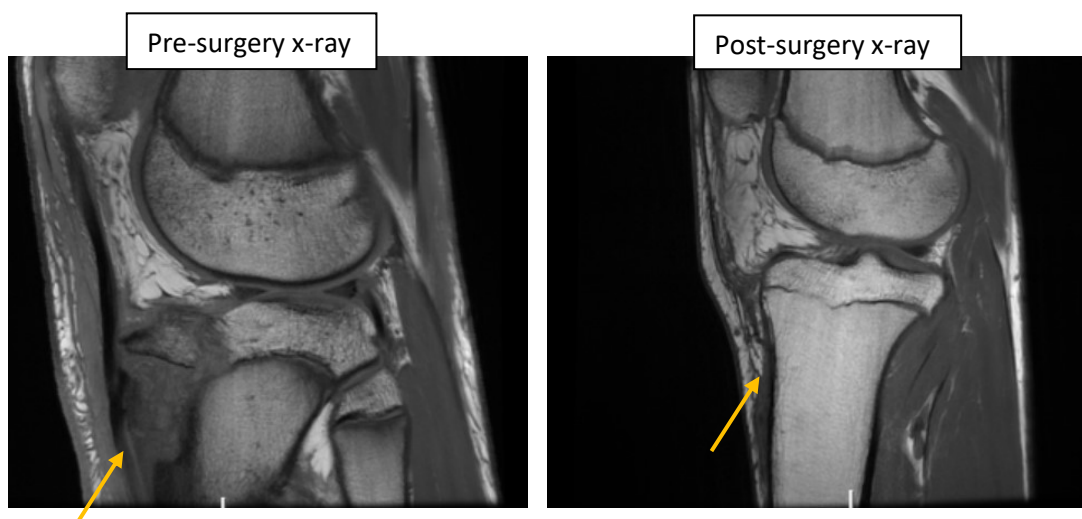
Player B pre- and post-surgery lateral MRI scans of the right proximal tibial avulsion injury
